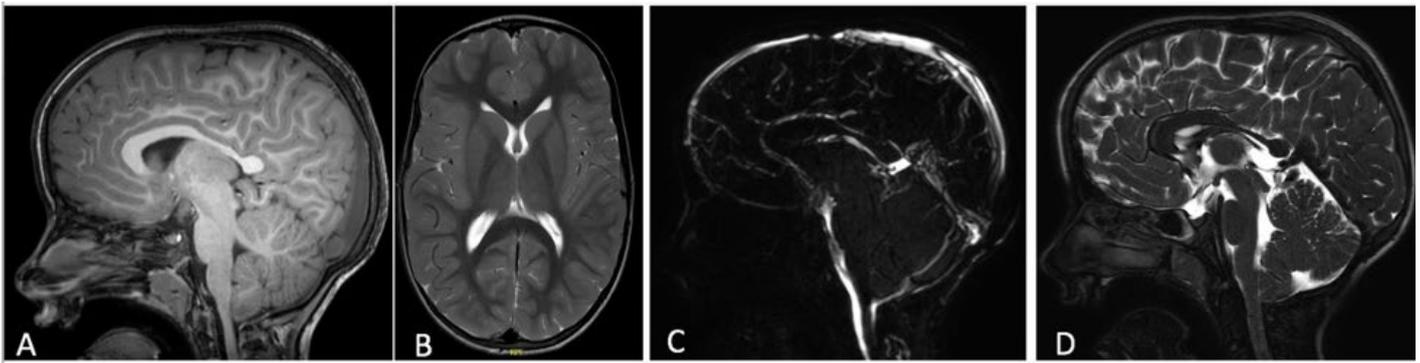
A–B) T1 sagittal and T2-weighted axial magnetic resonance brain images show a cranial deformity in the context of an early closure of the sagittal suture. There are no notable changes in the morphology and signal of the brain parenchyma; C) dynamic study of cerebrospinal fluid in flow MRI is normal, without any compromise of cerebrospinal fluid flow; D) T2-weighted sagittal magnetic resonance brain image demonstrates minor descent of the cerebellar tonsils through the foramen magnum at the lower limit of normality.
